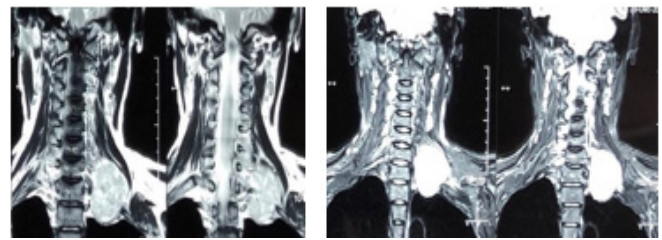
T1 and T2 image of MRI showing lesion in left paravertebral region at level of C7, D1 and D2 vertebral bodies
